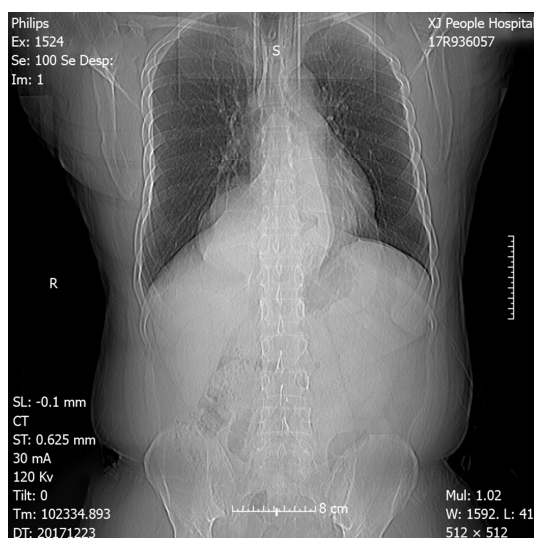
Postoperative chest x-ray at 1-mo follow up. There were no distinct abnormalities observed.
